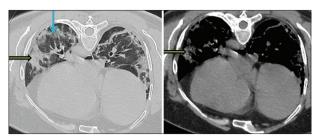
A 35 year old male patient presented with a history of fever, cough and dyspnea for last 7 days. Axial high-resolution computed tomography image (lung window) shows peripherally diffuse ground-glass opacities in both the lung fields
